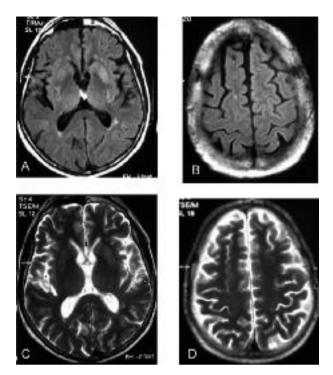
Axial FLAIR (A-B) and T2W MRI (C-D) images show bilateral subtle increase in signal intensity in the basal ganglia.
